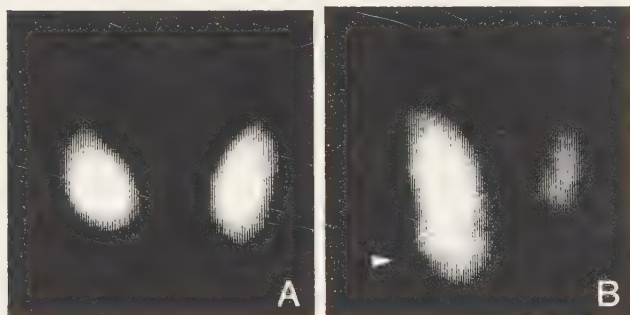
Apparently normal technetium-99m scintigram (A). Thallium-201 uptake extends outside the technetium image of the right lobe (arrow) (B)
